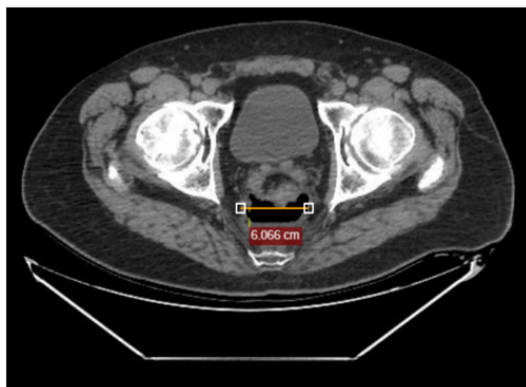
CT scan obtained before treatment showing a 6-cm presacral pelvic collection at the anastomotic site, with an air-fluid level (line).
